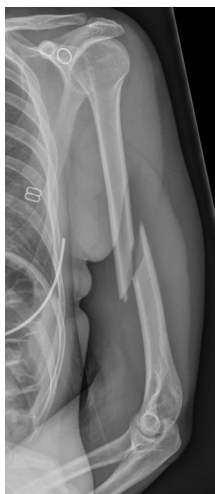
X-ray of spiral humeral shaft fracture.
